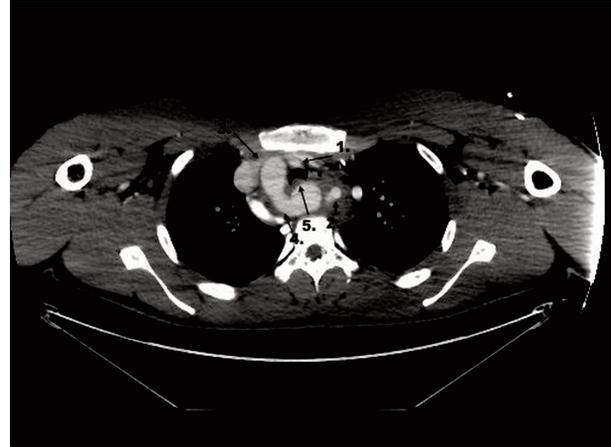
An axial plane contrast-enhanced CT image. The RAA branches off to give the LCCA (1) and aberrant LSA (2). The branching of the RCA (3) and RSA (4) is denoted. The pseudo-aneurysm (5) is also seen compressing the trachea.
